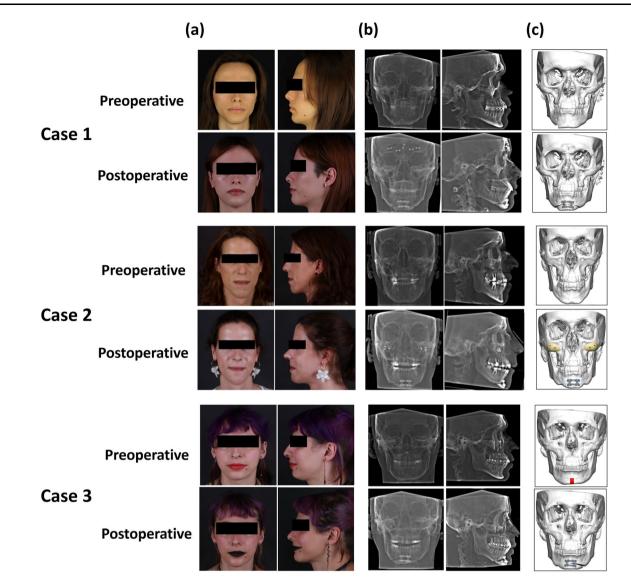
Preoperative and 3-month postoperative of three transgender patients who performed transverse genioplasty with chin advancement. Facial photographs (a); computed tomography (b); 3D reconstruction (c)
